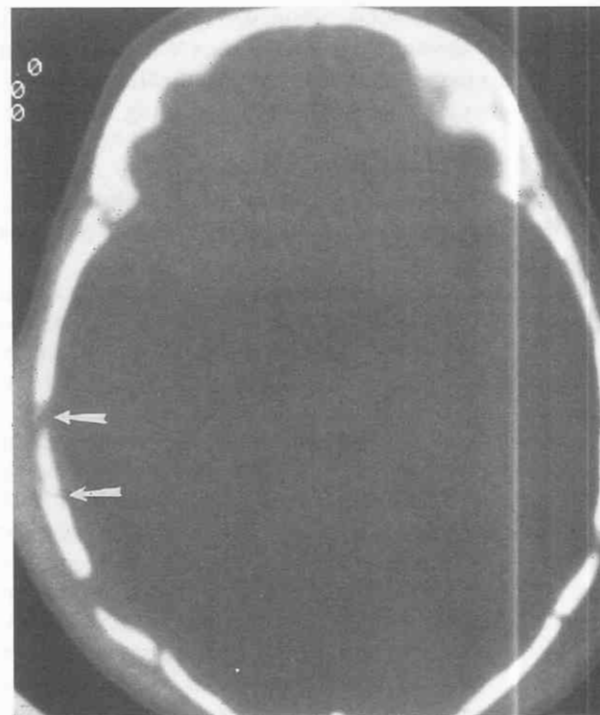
Axial CT scan with bone window setting shows nondepressed fractures of the right temporal bone (arrows).
